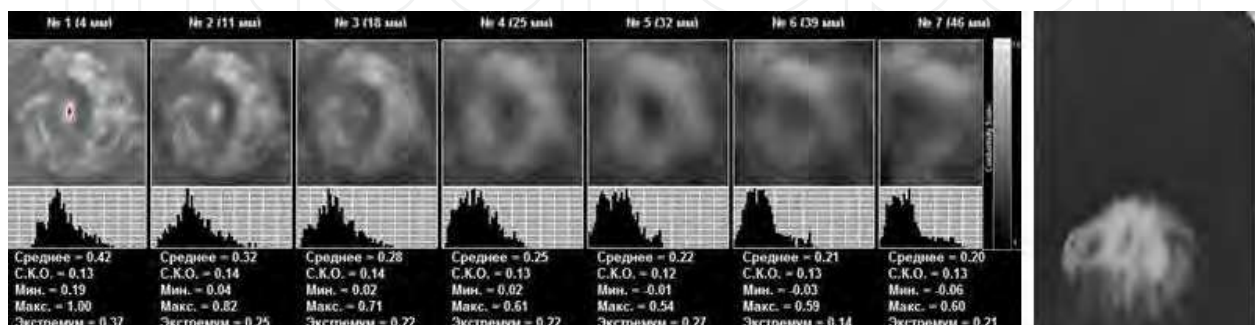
EIM. Seven scan planes. Age 39 years. Mixed type of mammary gland structure. Mean electrical conductivity index – 25-75 pct. On the right - X-ray mammogram.
